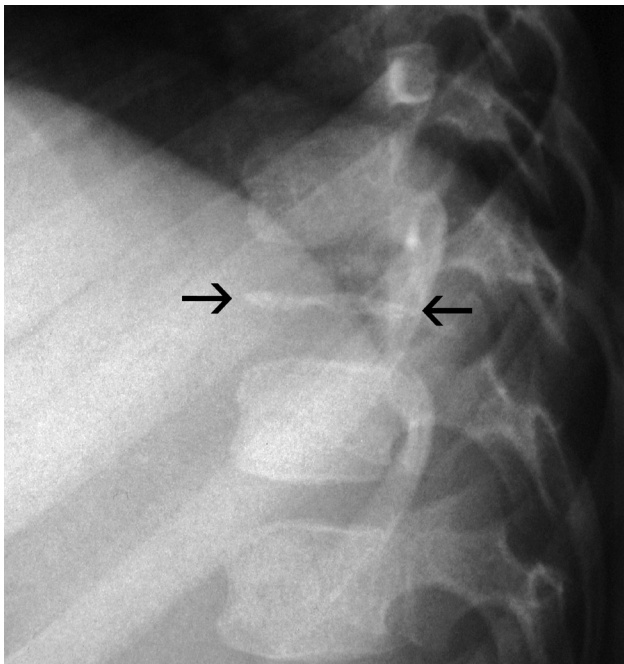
Classic vertebra plana of the lower thoracic spine in a 3-year-old boy with LCH. Conventional radiograph showing complete collapse of the vertebral body (straight arrows) with sclerosis of the residual bone.
